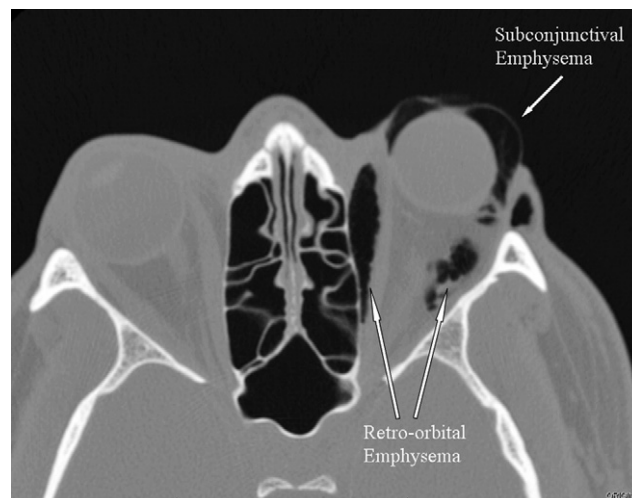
Computed tomographic orbits. Used with permission of Drew Weber, MD, the Department of Emergency Medicine and the Department of Ophthalmology, Wake Forest University Baptist Medical Center, Winston-Salem, NC.
